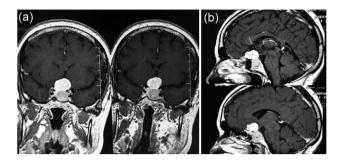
MRI showing (a) an intrasellar lesion isointense in T1W and T2W images enhancing homogenously and mildly after contrast material injection and (b) a suprasellar lesion $3 \times 3 \times 2$ cm in diameter with the same intensity in T1W and T2W images which enhanced notably after contrast material injection.
